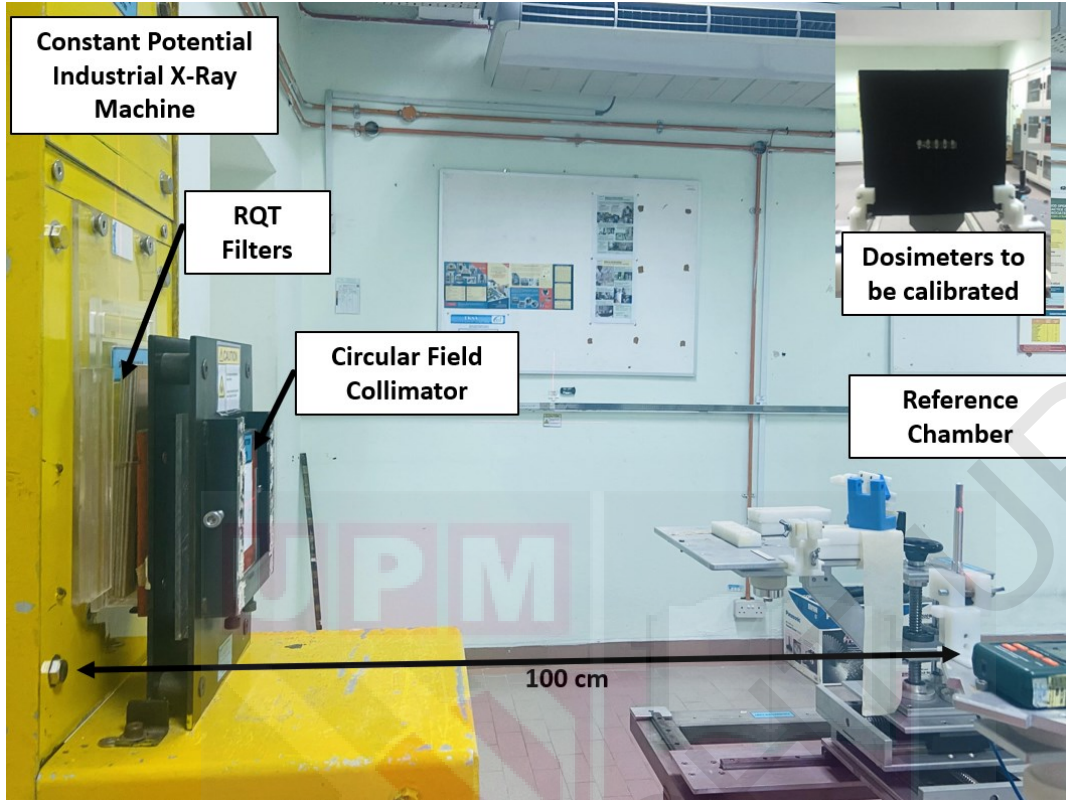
Calibration set-up of Constant Potential Philips Industrial X-ray machine with RQT 8 filters
